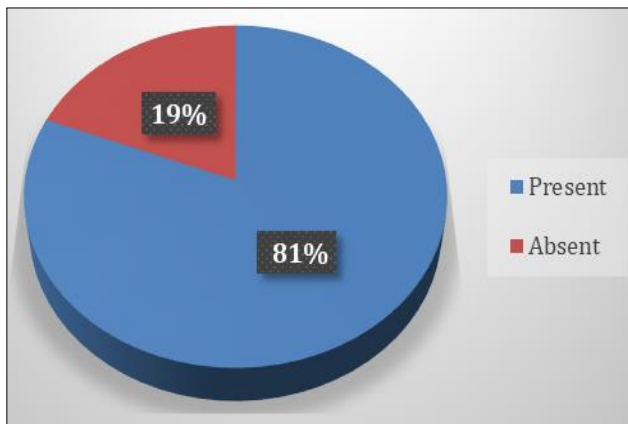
Percentage of patients with joint effusion on MRI
